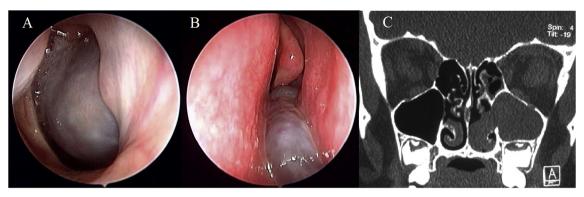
Endoscopic and radiological features of a left antrochoanal polyp (A: endoscopic endonasal view of the nasopharynx through the right nasal fossa, showing the choanal portion of the polyp; B: endoscopic endonasal view of the middle meatus; C: coronal CT scan showing the polyp arising from the maxillary sinus).
